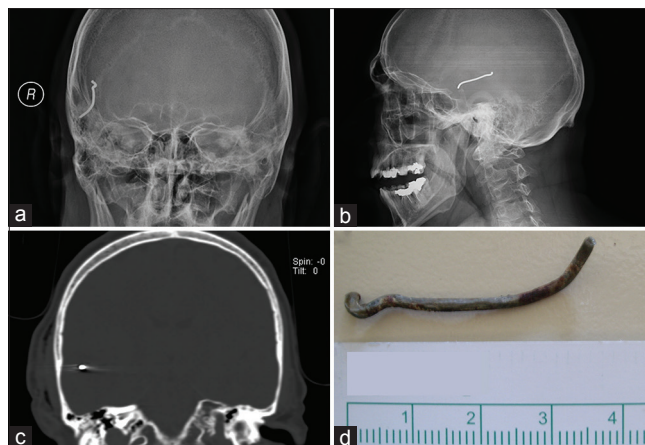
(a and b) Skull X-ray revealing the presence of a foreign body. (c) Coronal computed tomography. (d) Photograph showing the foreign body
